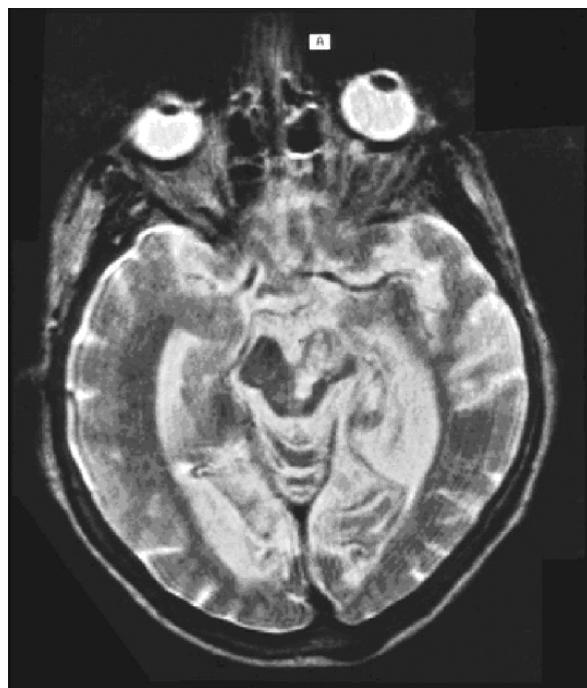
An infarct in the region of the left midbrain peduncle (MRI T2-weighted imaging).
